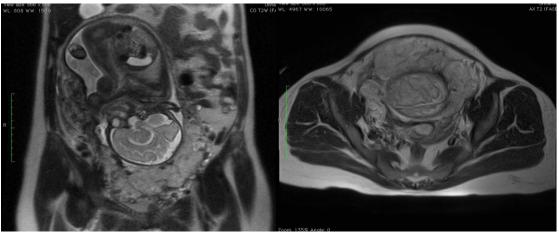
T2 weighted coronal and axial MRI images of one the patient with invasive placenta, showing heterogeneous placenta with focal uterine bulging and multiple thick intra-placental bands
